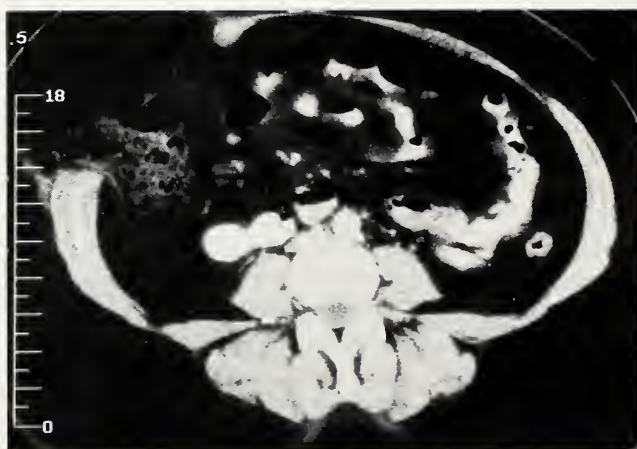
Admission CT scan of the abdomen showing disruption of the musculature and herniation of bowel into the defect.
